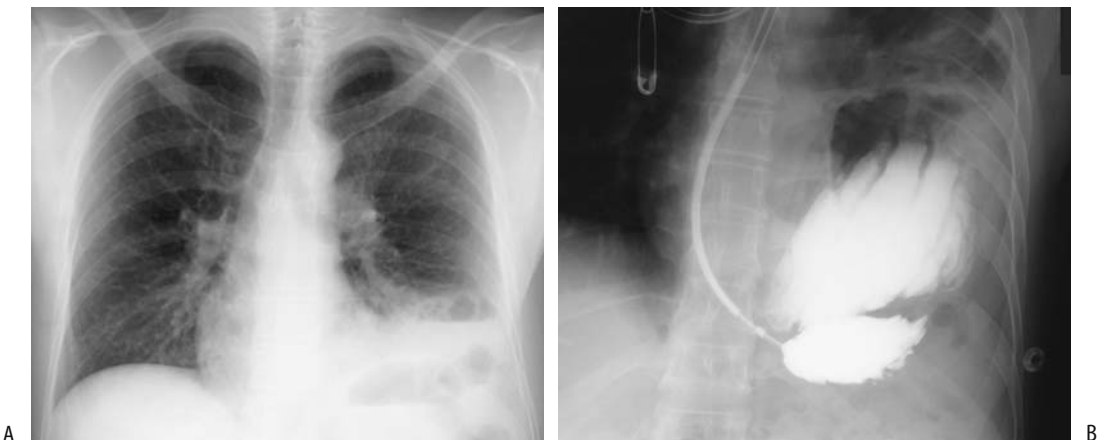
Traumatic left hemidiaphragm rupture. A: Chest radiograph reveals gas and fluid at the left lung base. B: A barium study performed through a nasogastric tube identifies part of the stomach in the chest. This study was performed several hours after that in part A, and now considerably more abdominal content has herniated into the chest.
